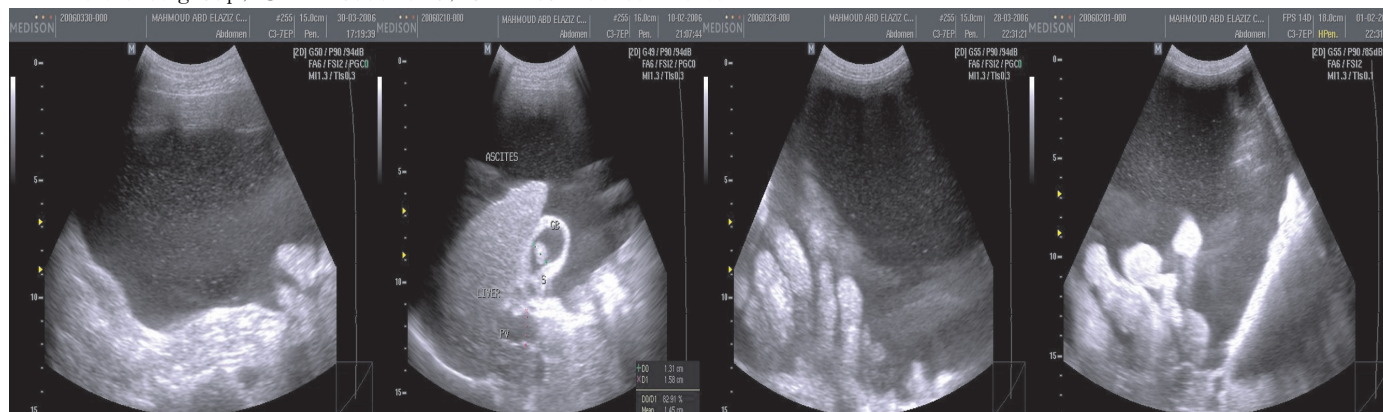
Abdominal ultrasonography showing ascetic fluid with numerous fine hyper-echoic internal particulates in patients with SBP
